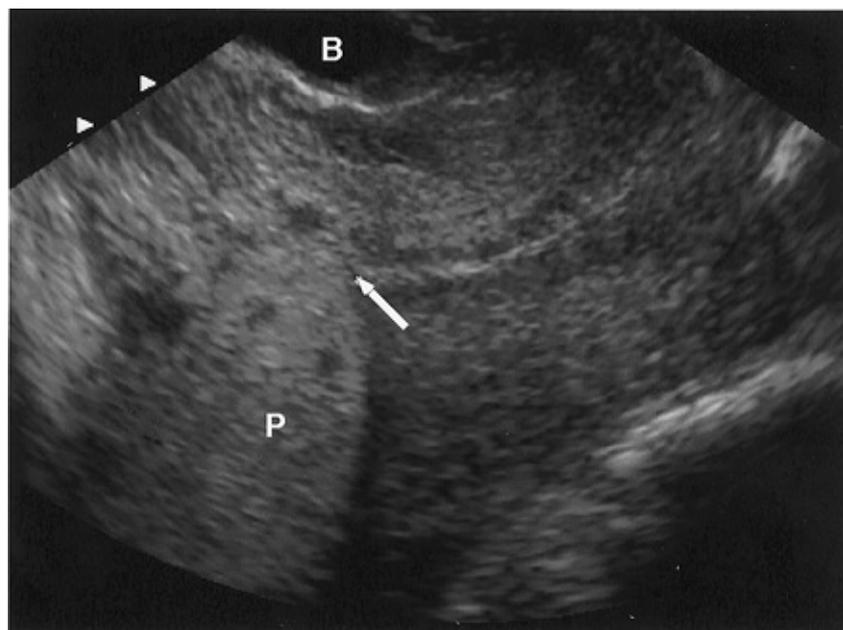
A transvaginal ultrasound image of a complete placenta previa. The *arrow* points to the internal os. (*P*, placenta; *B*, bladder.)
